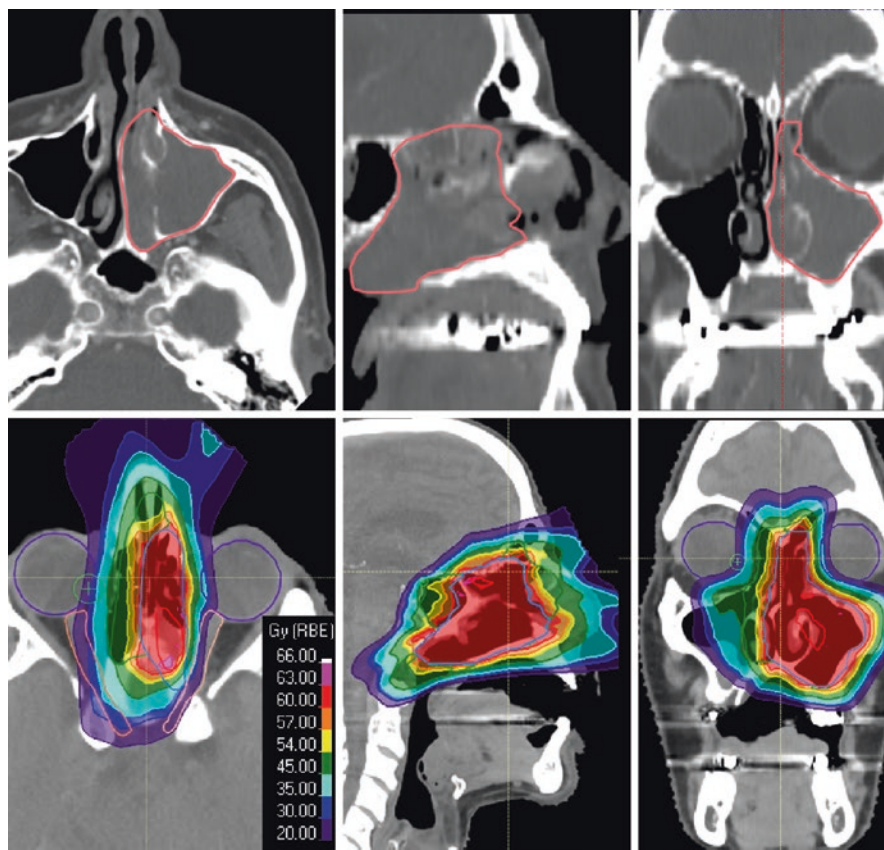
This patient presented with nasal obstructive symptoms and a 6-month history of epistaxis. A non-contrast CT showed a left nasal polypoid mass with opacification of the left ethmoids and maxillary sinus. An endoscopic excisional biopsy and debulking was performed that noted tumor in the maxillary sinus. Pathology showed a mucosal melanoma. Subsequent PET/CT and MRI showed no regional or distant metastatic disease and the patient was staged cT3 N0 M0. Surgery was recommended including maxillectomy with obturation, which the patient declined. Definitive radiation was then offered with hypofractionated proton therapy. A dose of 60 Gy in 15 fractions covered the preoperative tumor volume with margin including the left nasal cavity, ethmoids, and maxillary sinus with an elective dose of 45 Gy in 15 fractions covering the contralateral right nasal cavity, ethmoids, and remainder of the sphenoid sinus. The patient had no evidence of disease 2-1/2 years after treatment
